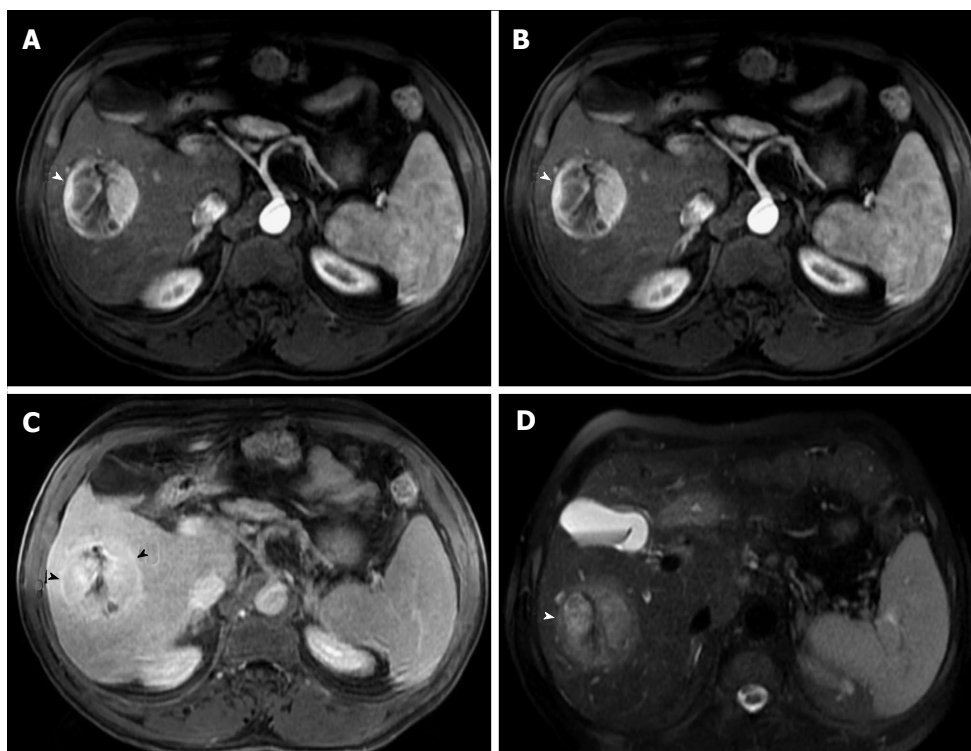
Large hepatocellular carcinoma with delayed pseudocapsule enhancement but no intralesional washout. Post-contrast fat-suppressed 3D-GRE T1-weighted images during the (A) late hepatic arterial, (B) portal venous, and (C) delayed phases; D: Fat-suppressed SSFSE T2-weighted image. There is a large right hepatic lobe mass, which demonstrates heterogeneous, intensely increased arterial enhancement (arrowhead, A) with progressive fading throughout the subsequent images (B), but no clear washout (C). The lesion demonstrates delayed pseudocapsular enhancement (black arrowheads, C) and mildly increased T2 signal intensity (arrowhead, D) in keeping with a large HCC. HCC: Hepatocellular carcinoma; GRE: Gradient recalled echo; SSFSE: Single-shot fast spin-echo.
